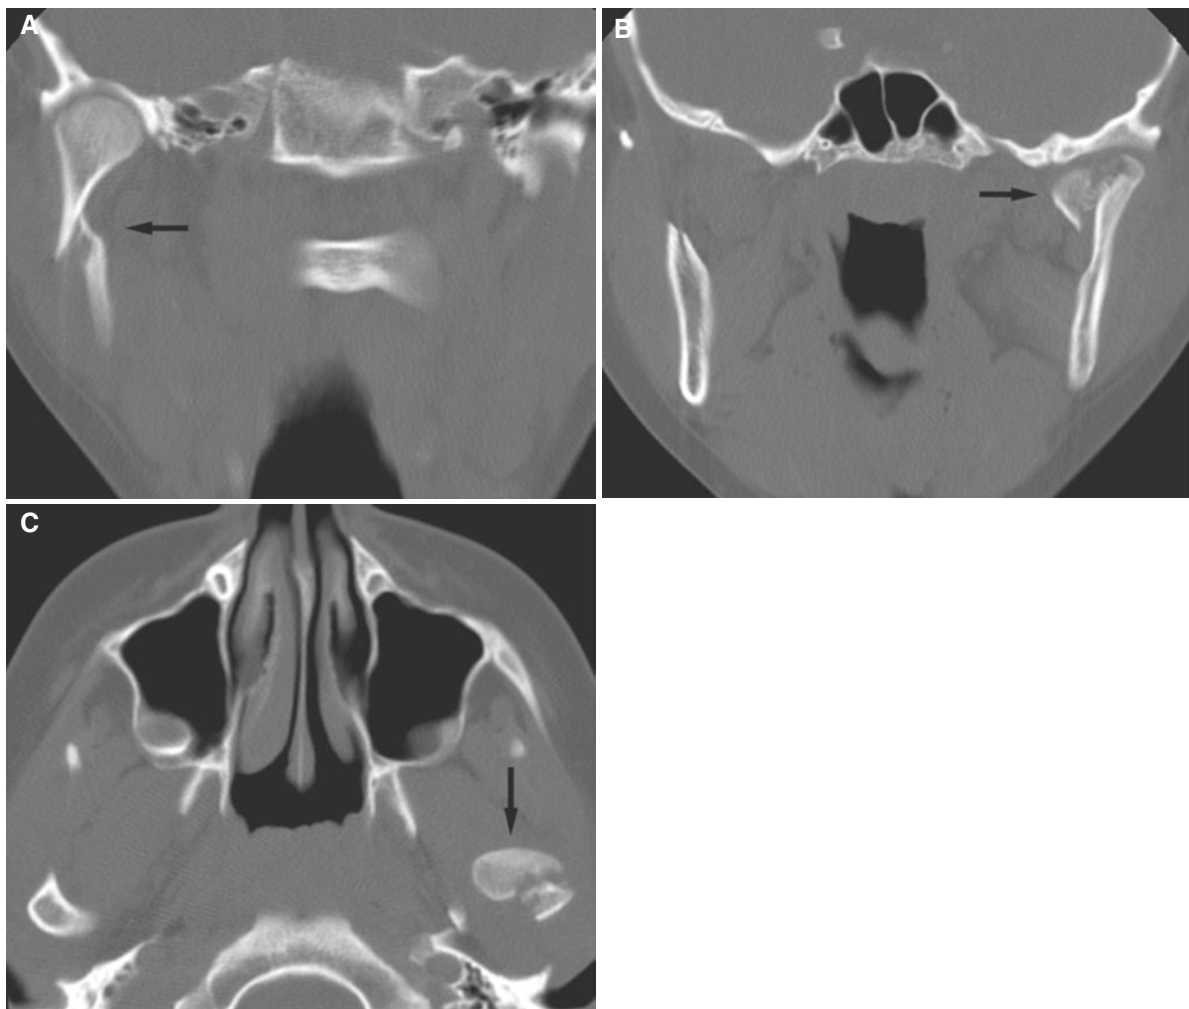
Mandibular neck and contralateral mandibular condyle fractures; 10-year-old male who fell over handlebars of his bike, landing on his chin. (A) Coronal CT shows right mandibular neck fracture (*arrow*). (B) Coronal CT shows intracapsular fracture of contralateral
